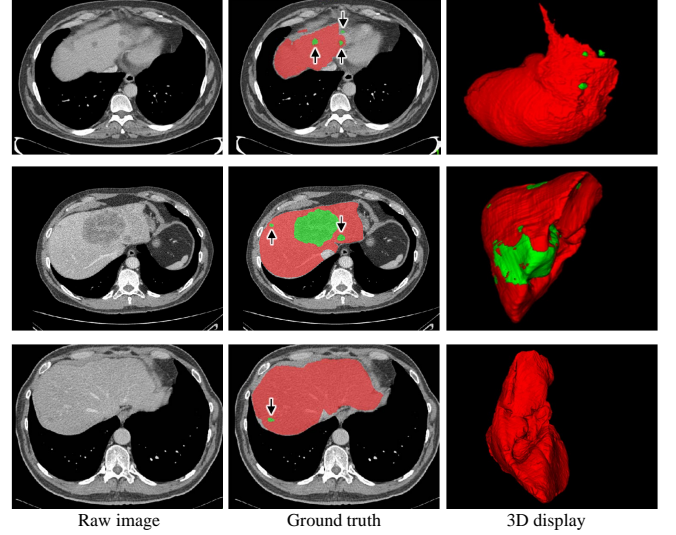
Examples of contrast-enhanced CT scans showing the large variations of shape, size, location of liver lesion. Each row shows a CT scan acquired from individual patient. The *red* regions denote the liver while the *green* ones denote the lesions (see the black arrows above).
